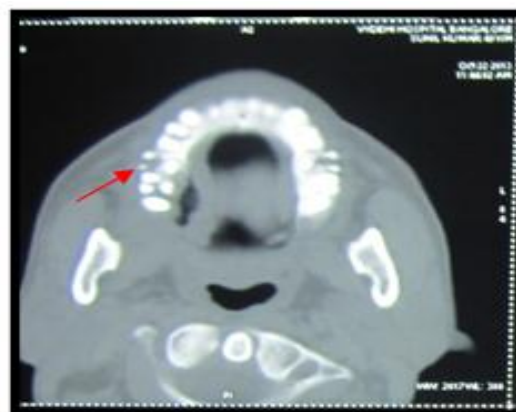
Computed Tomography shows erosion of alveolar bone in right posterior maxilla
